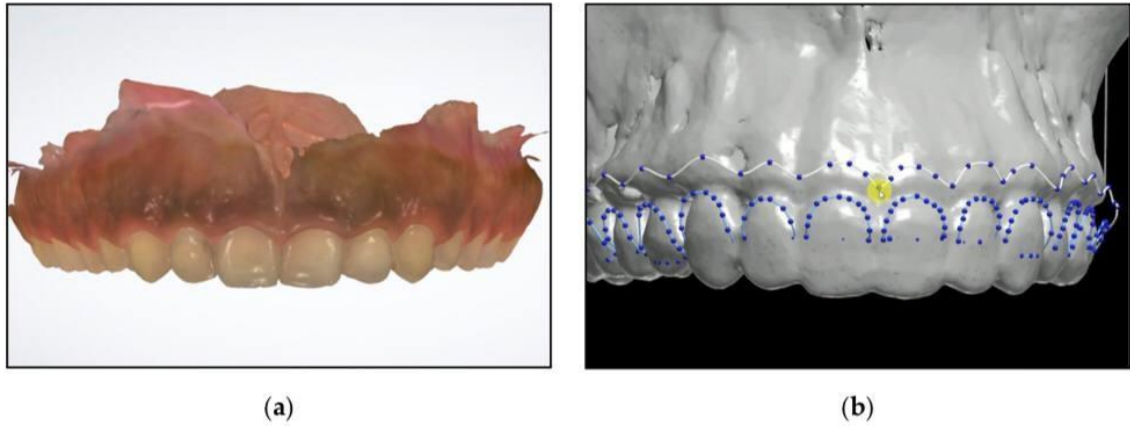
(a) Intraoral scan of the maxillary jaw; (b) After superimposition of the CBCT and the intraoral scan, the cemento-enamel junction and future bone level marked. [121]
